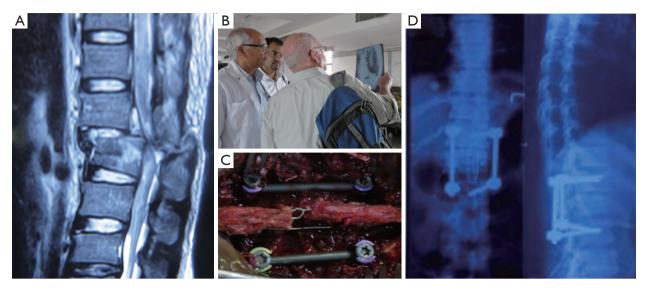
Patient #2 (A) Preoperative MRI; (B) Prof Giri of Bir Hospital and Dr Sutterlin of Spinal Health International (SHI); (C) intraoperative photo; (D) postoperative X-ray.
